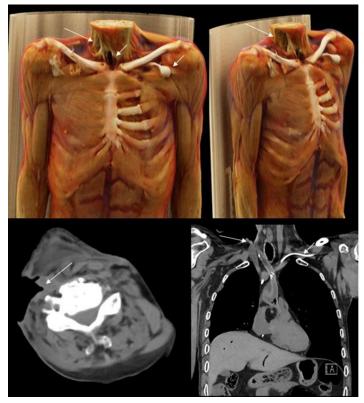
Upper row: 3-D Cinematic Rendering, Lower row: CT virtopsy with axial and coronal reconstruction. Long arrow: Broad, extensive, deep soft tissue defect after opening the cervical soft tissues on the right side with a knife in an oncological patient with the intention to remove "tumor tissue." This resulted in accidental opening of the carotid artery and jugular vein with subsequent bleeding. Signs of hypovolemia with collapsed heart chambers and collapsed thoracic aorta. Short arrows: Tracheostoma defect of the jugulum and left pectoral Port-a-Cath system. Note that the cinematic rendering gives a more detailed impression of the trauma sites, making them easier to interpret and comprehend.
